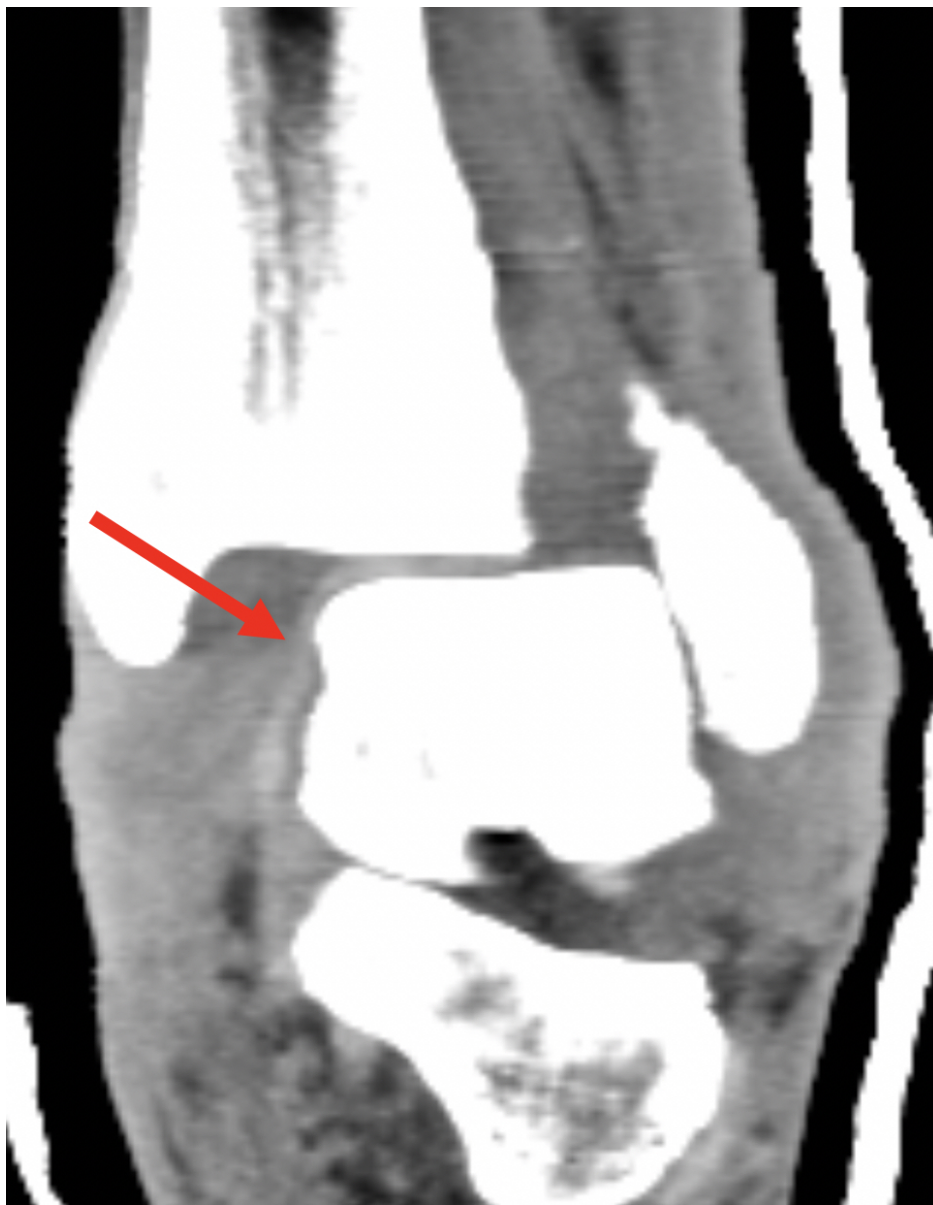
CT in coronal plane demonstrating PTT entering tibiotalar joint space with anterolateral displacement of the talus.
